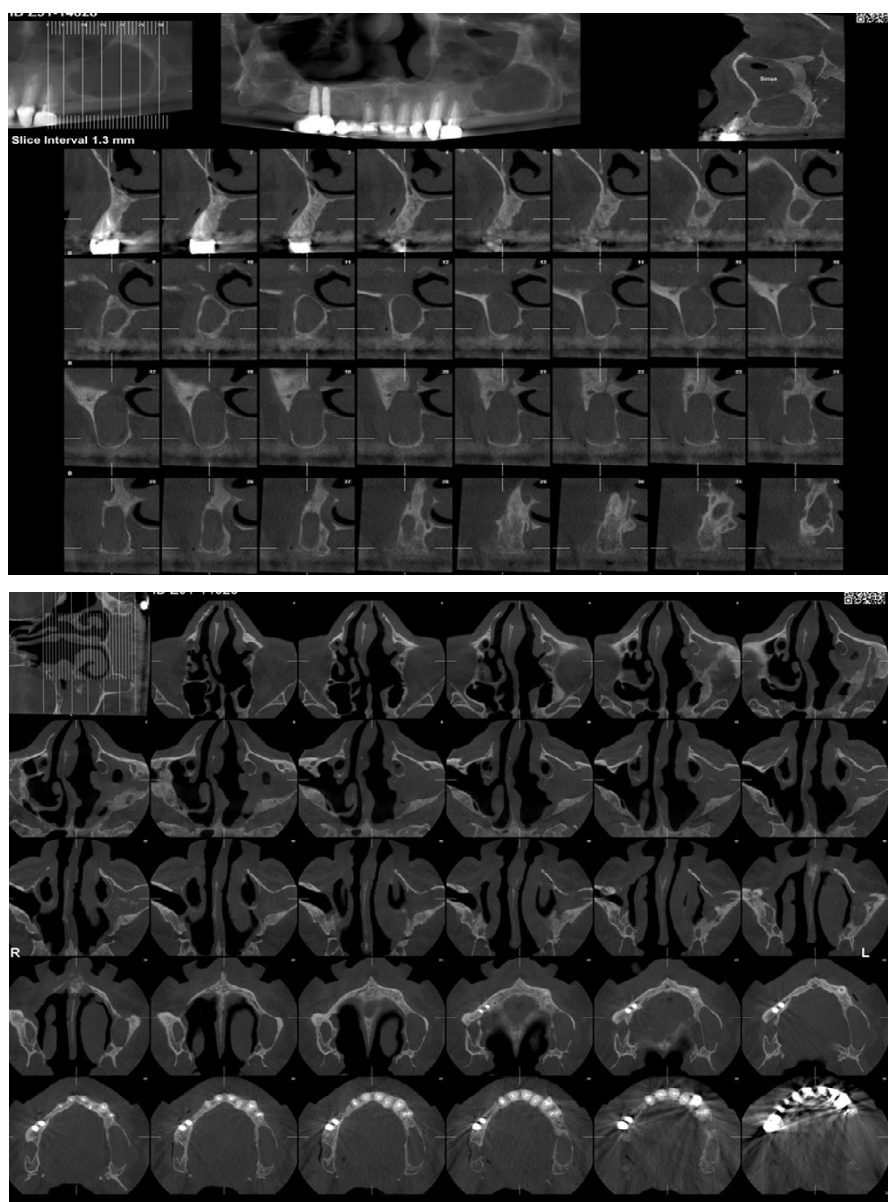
CBCT view showed cystic lesion near the maxillary sinus, with destruction of buccal cortex and thinning of lingual cortex
